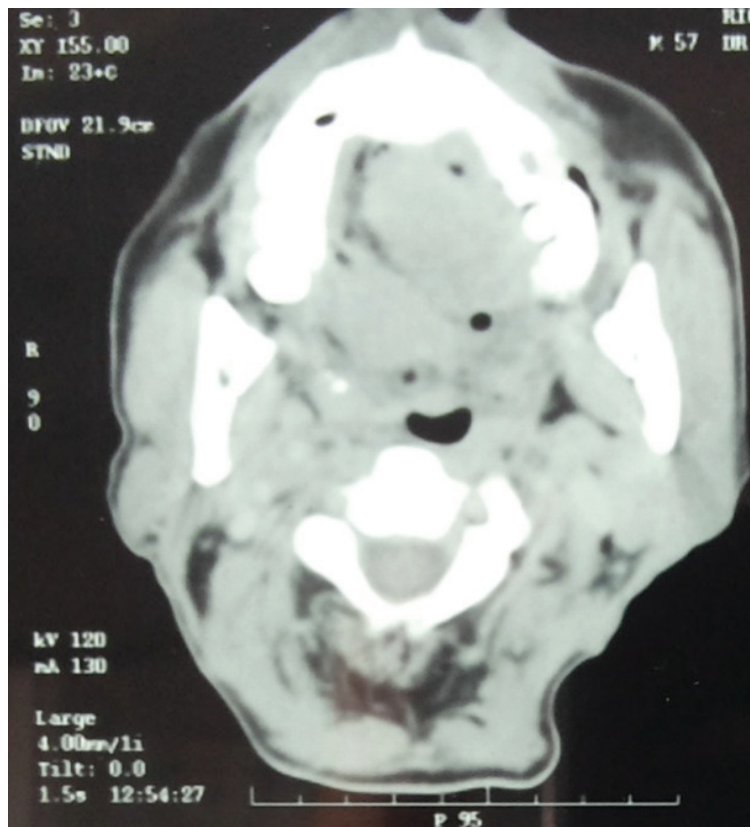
CT image showing well defined enhancing lesion in the left side of the oral cavity
